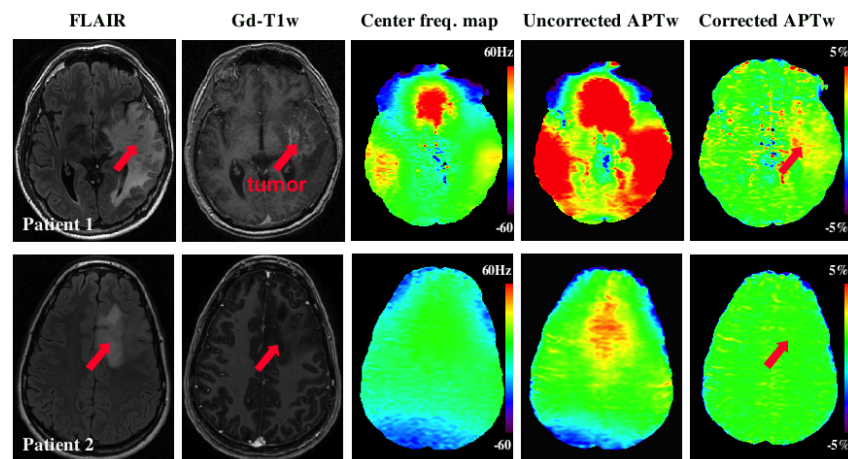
(left). APT-weighted images compared with other types of MRI. Patient 1: grade III oligodendroglioma. Patient 2: Low-grade oligodendroglioma.
